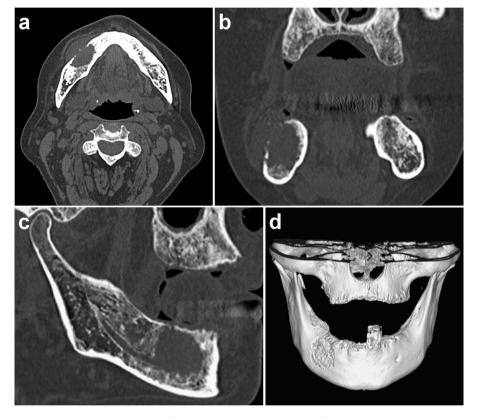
(a) Axial CT shows an osteolytic lesion with the destruction of buccal cortex in the right mandible. (b) The buccal cortex shows a moth-eaten appearance on a coronal reformatted CT. (c) Sagittal reformatted CT shows the lesion affecting the mandibular canal. (d) Three-dimensional reconstructed CT shows the lesion affecting the mental foramen.
